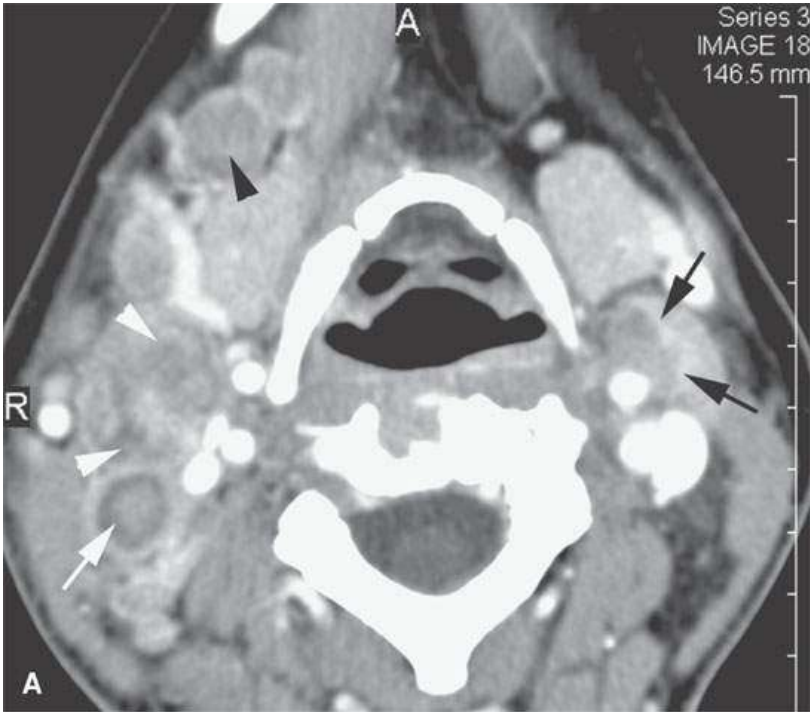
Contrast-enhanced computed tomography of an aggressive lymphoma. A, B: Multiple small positive nodes, many with focal defects due to lymphomatous deposits (*arrows*). C: Meningeal lymphomatous involvement (*arrows*). D: Perineural involvement of V2 at the foramen ovale (*arrow*).
